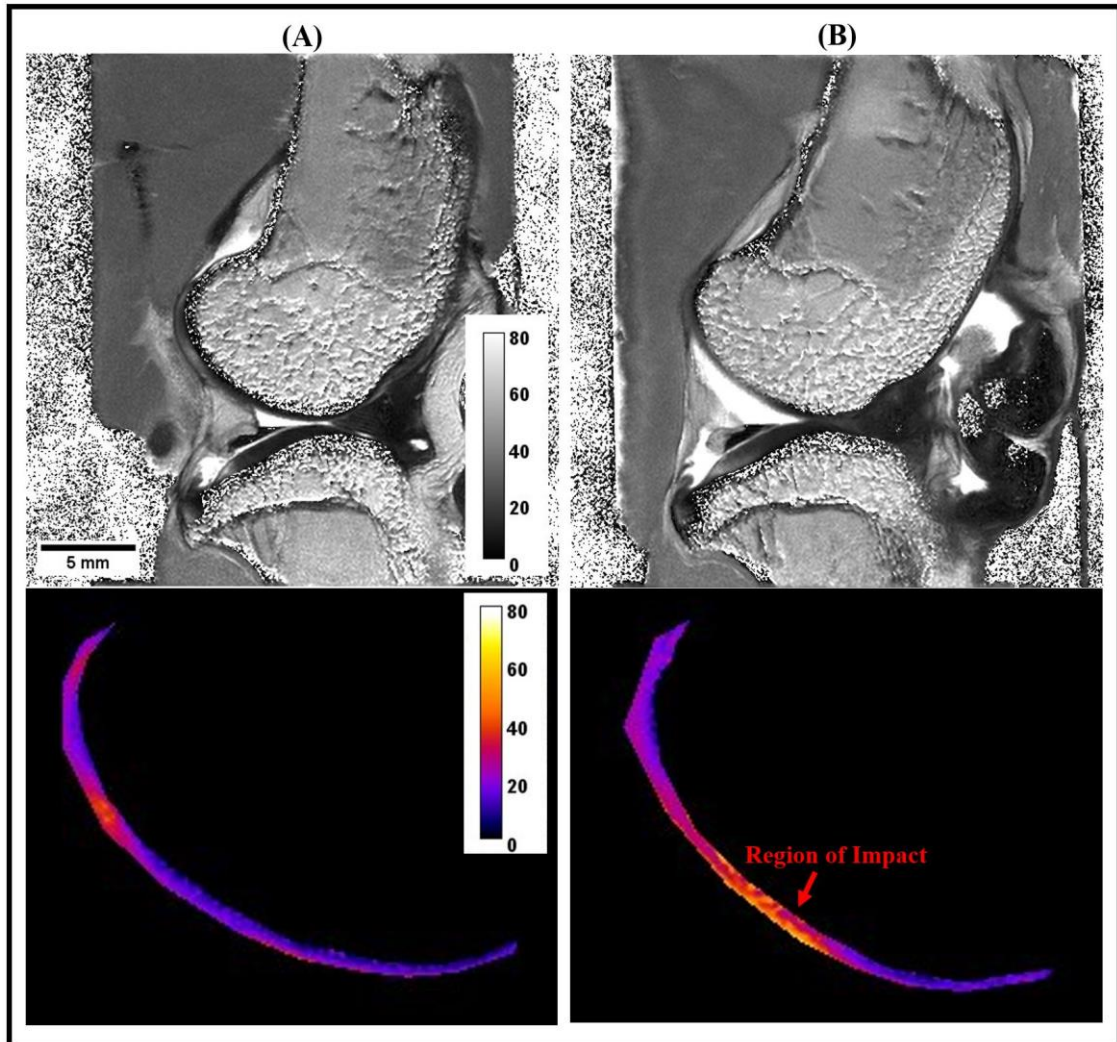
Representative MRI T2 maps of knee imaged at 14 weeks post-impact: (A) Non-Impact and (B) Impact. Below each main grey-scale image, the colored T2 maps of cartilage provide a zoomed-in view of the soft tissue. The hotter color (Orange) represents more cartilage degradation.
